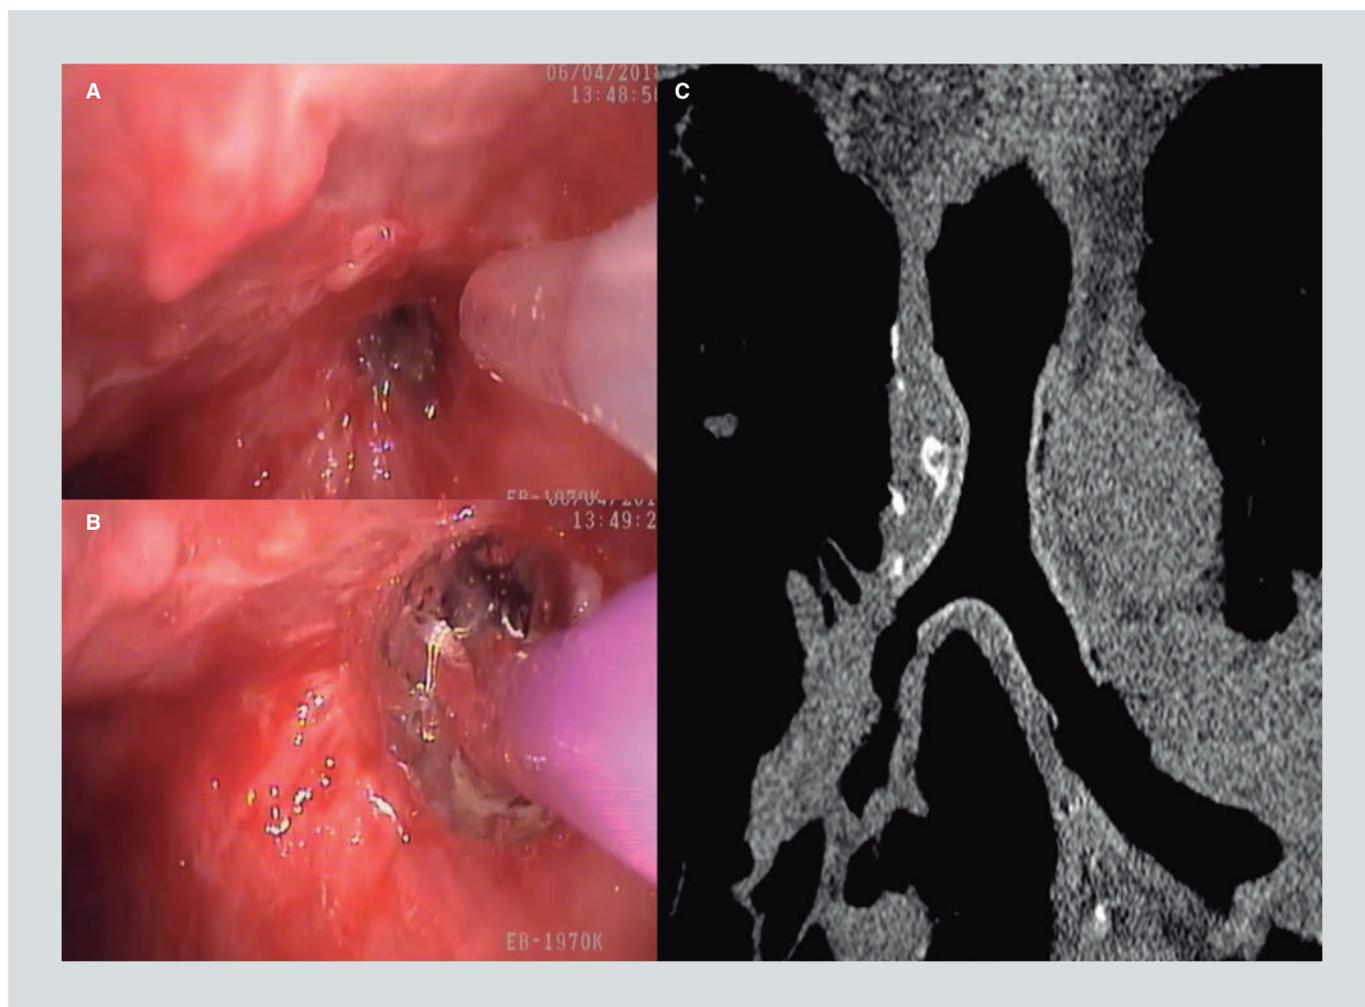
Example of a patient (from the DASCAS trial) treated with a 3D stent for an anastomotic complication after sleeve lobectomy. Commercially available stents failed: due to the difference in caliber between the right (thin stenotic *bronchus intermedius*) and left branches (normal left main bronchus), silicone Y stents could not be used (the right branch would not unfold) and bifurcated SEMS induced dramatic and stenosing granulation tissue reaction on the right side. A: visualization of the orifice of the *bronchus intermedius* after perforation with electrocoagulation, allowing for the passage of a dilation balloon. B: balloon dilation of the stenosis. C: CT scan one week after 3D stent implantation. Note the good congruence with the airways and the difference in caliber of the right and left branches of the stent. DASCAS: Dedicated Airway Stents for Central Airway Stenoses; SEMS: self-expandable metallic stents.
